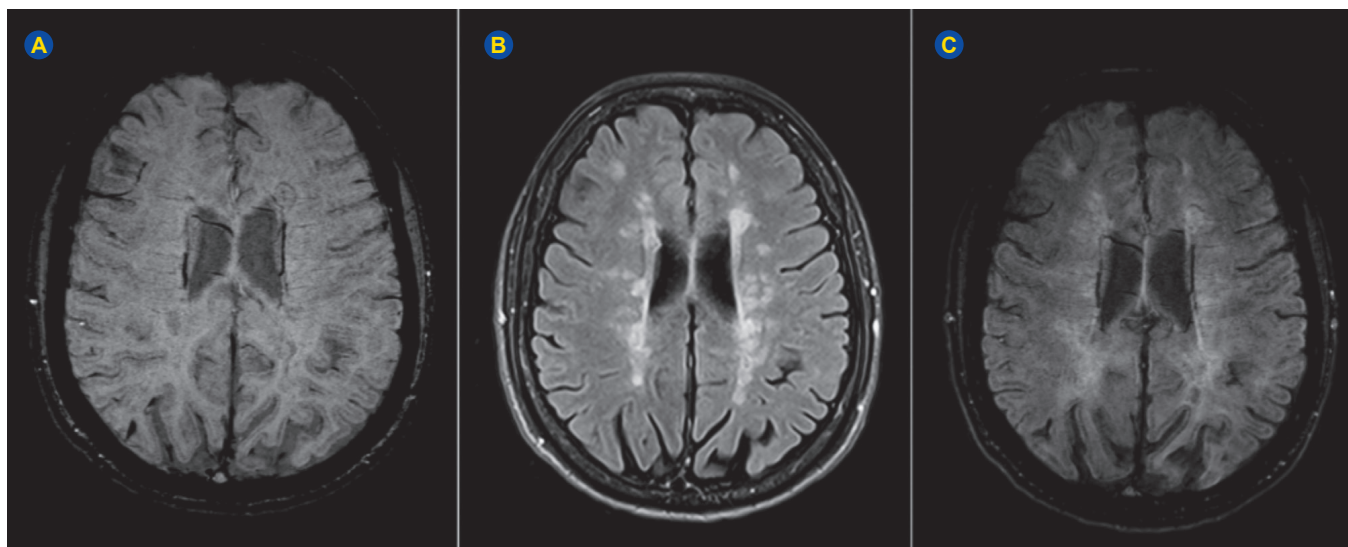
(A) Susceptibility-weighted imaging (MIP). (B) Axial reconstruction of 3D T2-FLAIR. (C) Fused image (A+B). MS lesions tend to be distributed along the course of deep medullary veins, a phenomenon that can be depicted in fused SWI-FLAIR images, contributing to the differential diagnosis
